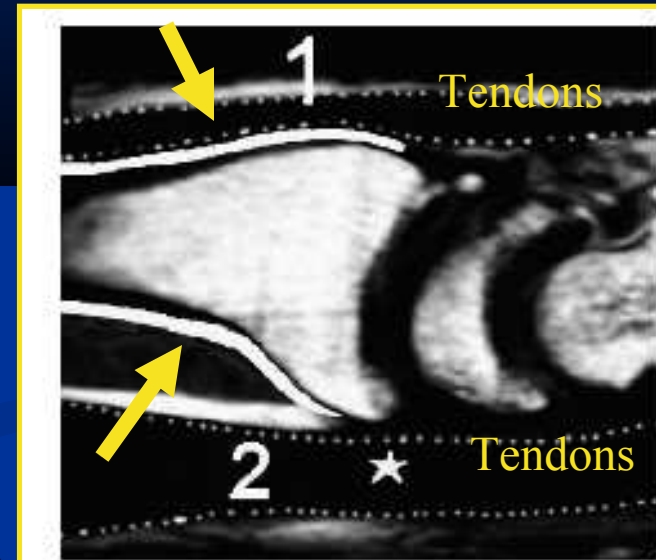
(A) The extensor tendons run in intimate contact with dorsal plates. The flexor tendons only approach the volar radius at the watershed line (*). (B) Magnetic resonance imaging shows the flexor tendons are well separated from volar plates. The best location for the application of fracture implants is the volar aspect of the distal radius. Reprinted from Orbay J. Volar plate fixation of distal radius fractures. *Hand Clin.* 2005; 21:347-354 with permission from Elsevier.
